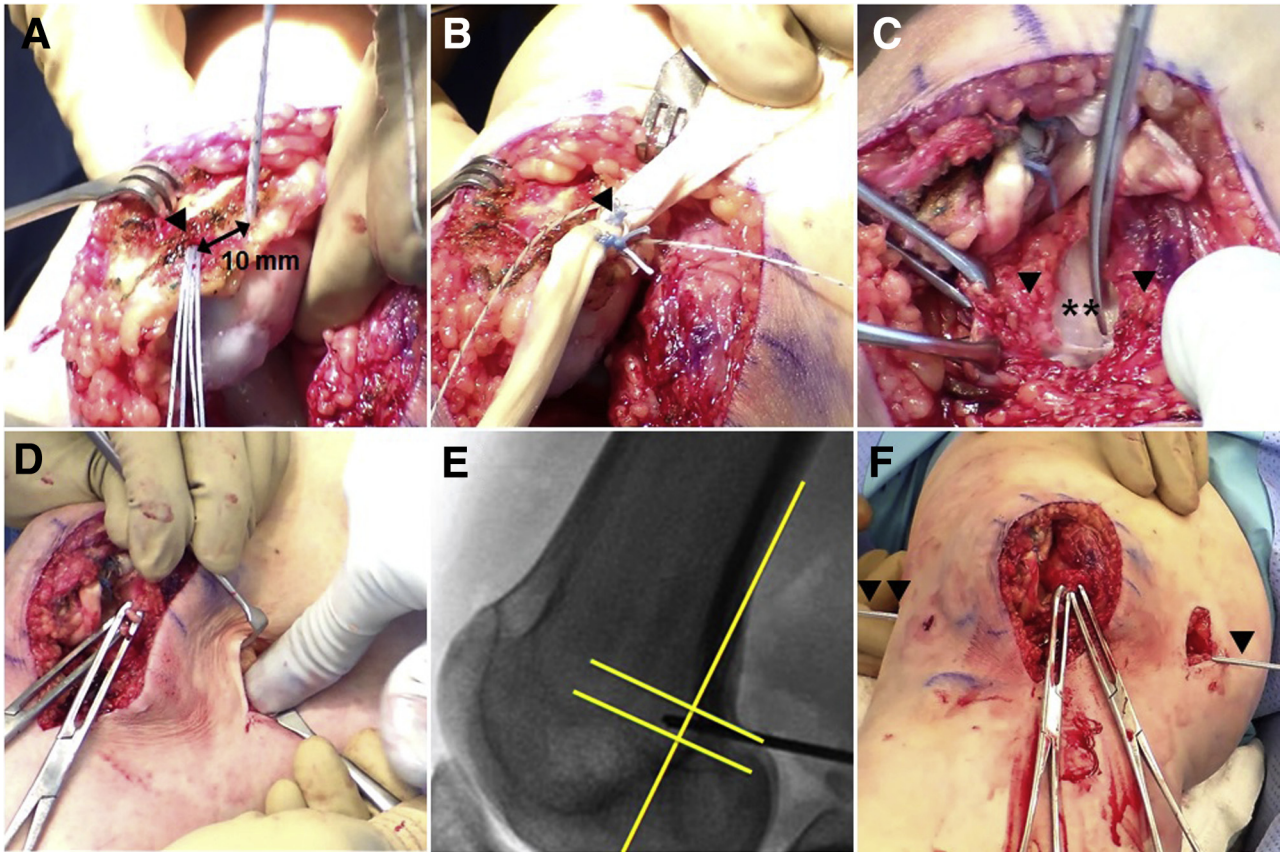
(A) After exposure and debridement of the upper half of the medial patella, two 3.0-mm PEEK SutureTak suture anchors (Arthrex) are inserted with the inferior anchor at the patellar equator (arrowhead) and the superior anchor 10 mm proximal. (B) The semitendinosus allograft is folded in half, and its looped end is secured with FiberWire suture (arrowhead). (C) After security is checked, the capsular layer between layers 2 and 3 (arrowheads) of the medial knee (asterisks) is dissected for graft passage. (D) The saddle between the adductor tubercle and medial epicondyle is exposed, palpated, and marked with a Beath pin. (E) Intraoperative fluoroscopy verifies the pin's position near the radiographic parameters of the Schottle's point (yellow lines). (F) The pin is then drilled (arrowheads) anterosuperiorly through the lateral femur.
